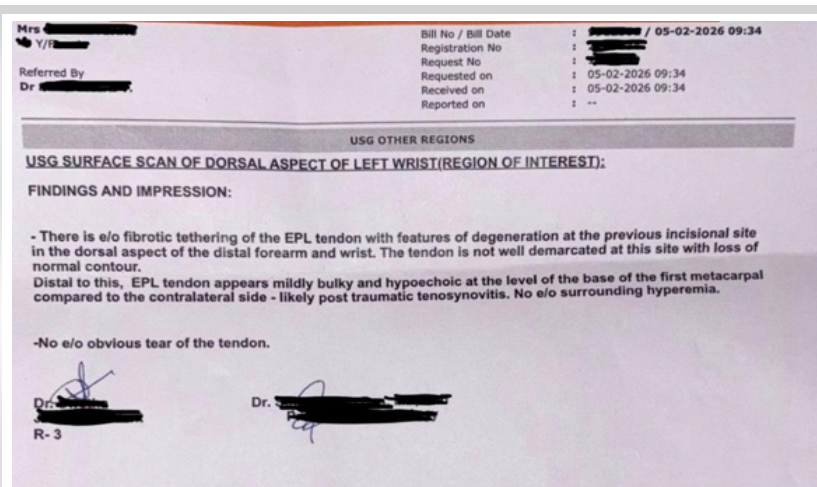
Pre-operative ultrasonography surface scan of the region of interest.
